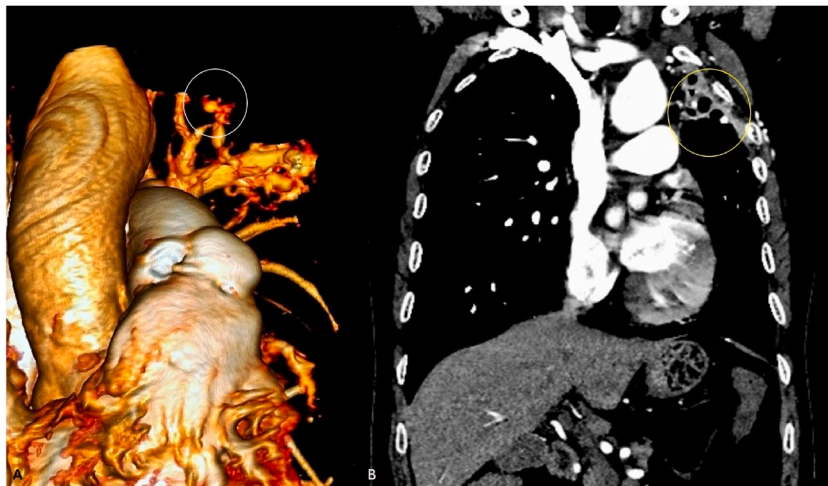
Case 2: A three dimensional reconstruction of the vascular anatomy (MDCT) showing an aneurysm originating from a left upper lobe segmental pulmonary artery branch on image A (encircled) corresponding to CT angiography on image B (encircled).
